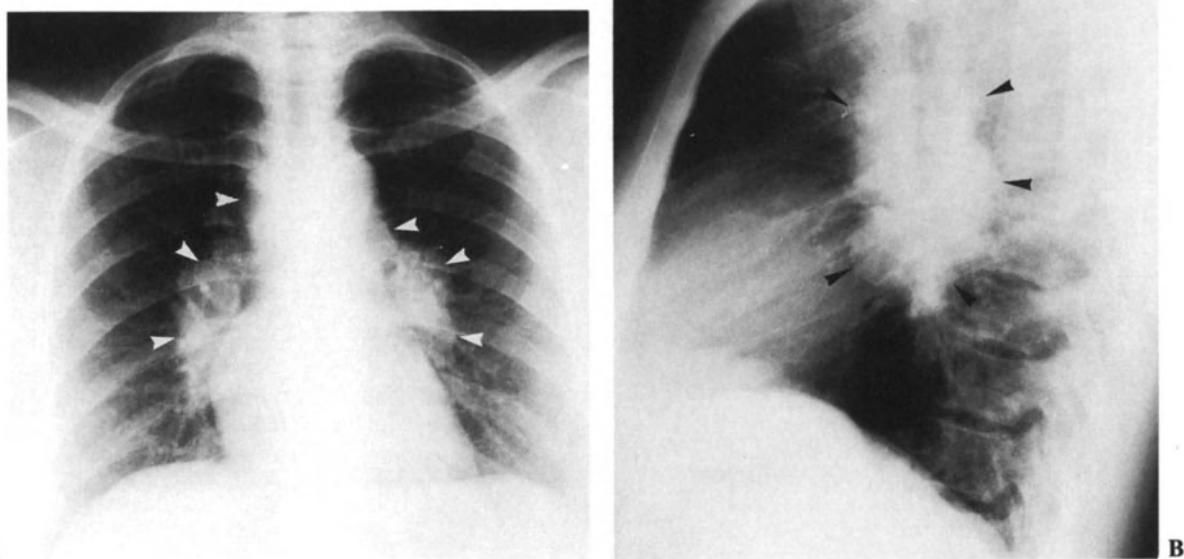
Lymphadenopathy. Oat cell carcinoma. Chest radiograph shows bilateral paratracheal and left hilar lymph node enlargement (*arrowheads*).
